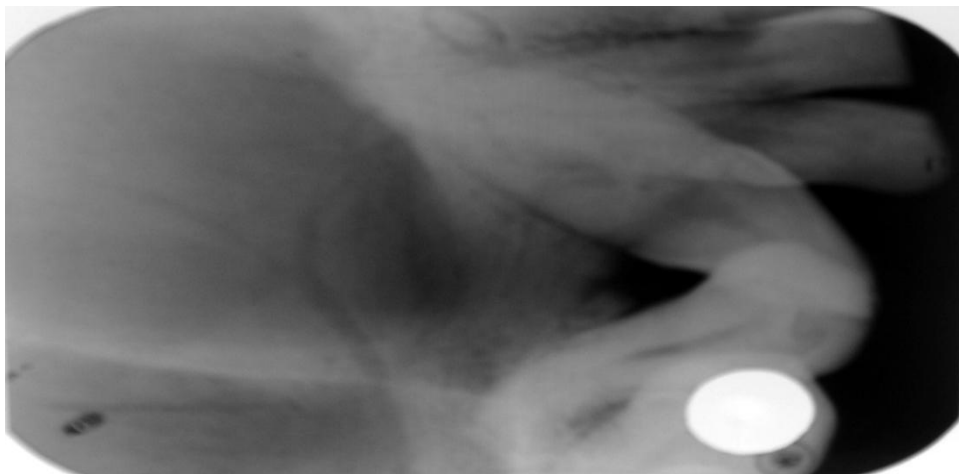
Intraoral Periapical Radiograph showing well defined, homogenous radiolucency
